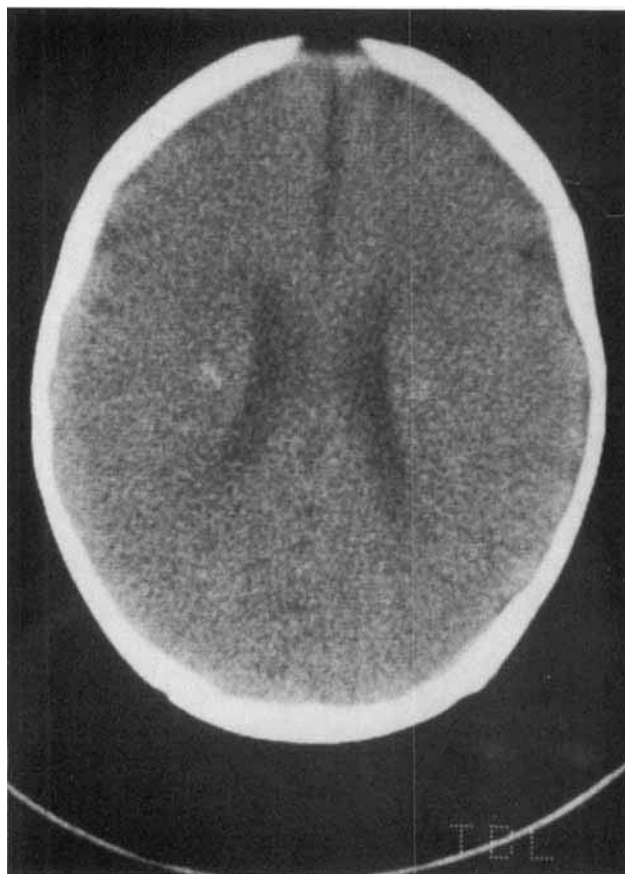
Axial CT in KD, infantile form. Case 1. Eight-month-old child presenting with hypertonia and seizures. Bilateral circumscribed hyperdensities in central white matter.
